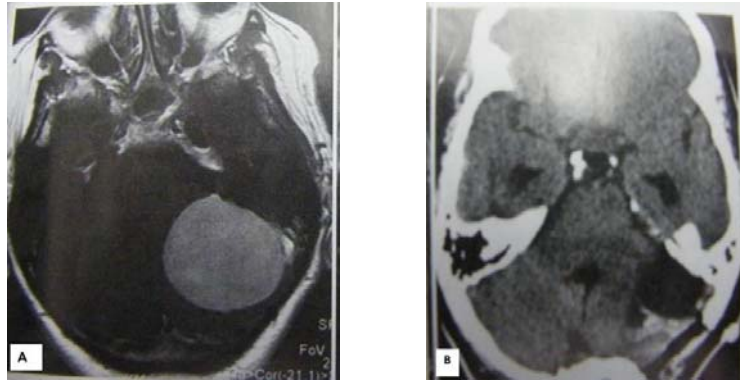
(A) preoperative T1 contrast-enhanced MR image revealing a postmeatal meningioma. (B) postoperative CT scan demonstrating complete tumour resection via a retrosigmoid approach.
